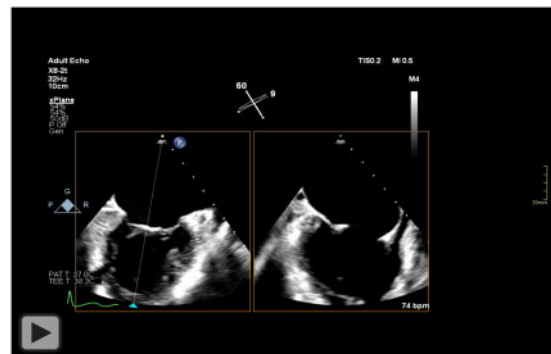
Transoesophageal echocardiogram images showing (A and B) thickened mitral valve leaflets with irregular-shaped, hyperechoic, nodular lesions located on both leaflet tips (yellow arrows), consistent with healed Libman–Sacks endocarditis. (C) Three-dimensional view showing multiple irregular-shaped nodularities of different sizes on both leaflet tips (red arrows), predominantly at A2/P2 and A3/P3 regions. (D and E) Severe mitral regurgitation from two mitral regurgitation jets, located medially at A3/P3, and centrally at A2/P2. (F) Pulmonary vein systolic flow reversal.
